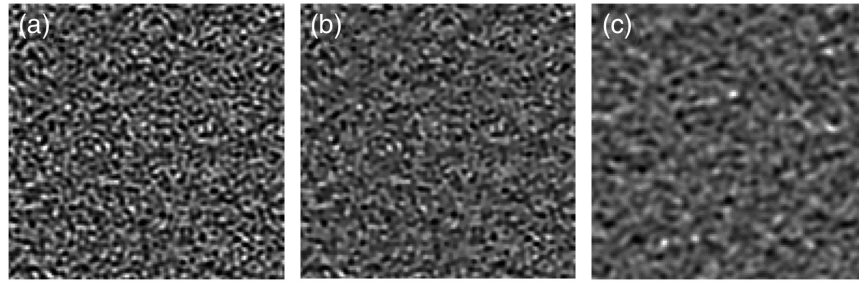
Comparison of noise magnitude and texture in a 128×128 pixel section of the water surroundings (window level/width: 40/400 HU) between (a) PCD-CT (original), (b) PCD-CT (denoised), and (c) EID-CT. Noise magnitude is similar in (b) and (c), but noise texture is not identical.
